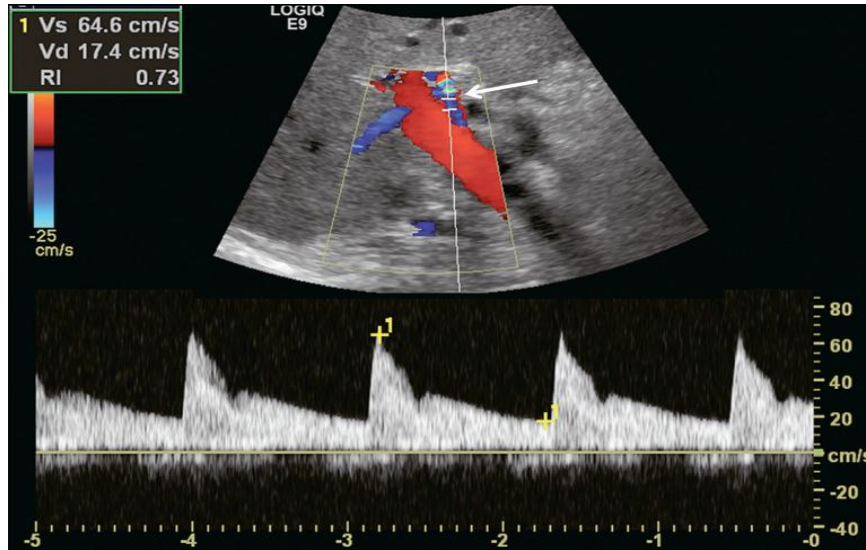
Spectral Doppler tracing of a normal hepatic artery. Systolic upstroke is brisk with acceleration time <0.07 s. Resistive index measures 73%. Velocity at end diastole approximates 17 cm/s.
